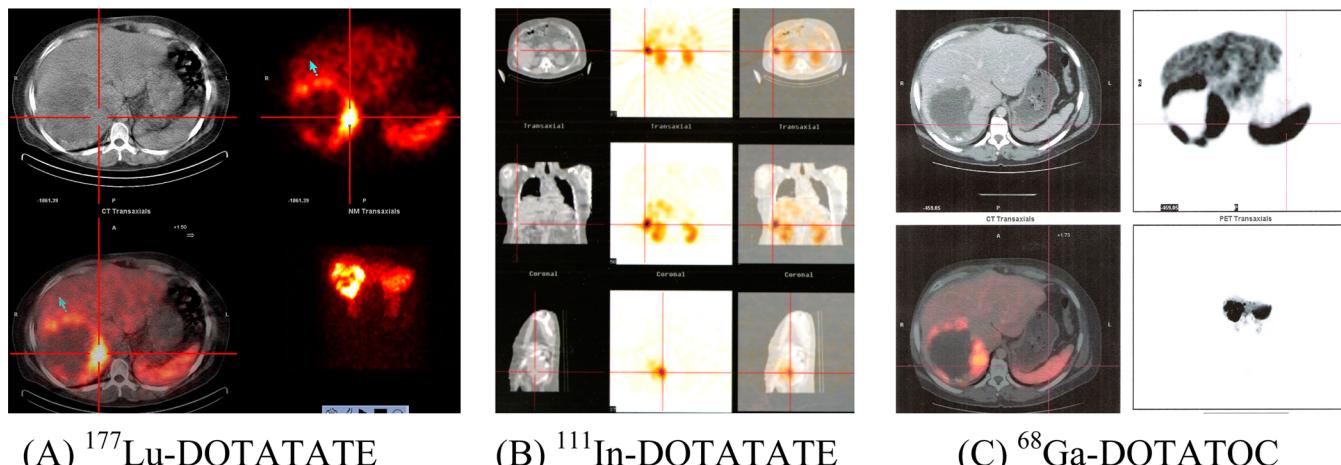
Comparison of (A) ^{177}Lu -DOTATATE SPECT-CT with ^{111}In -DOTATATE SPECT-CT and ^{68}Ga -DOTATATE PET-CT scans in the same patient. Reprinted with permission from ref 290. Copyright 2011 Society of Nuclear Medicine India.
